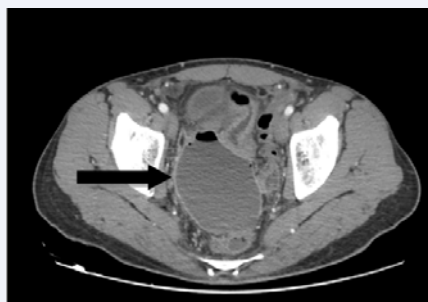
CT scan pelvic collection.
